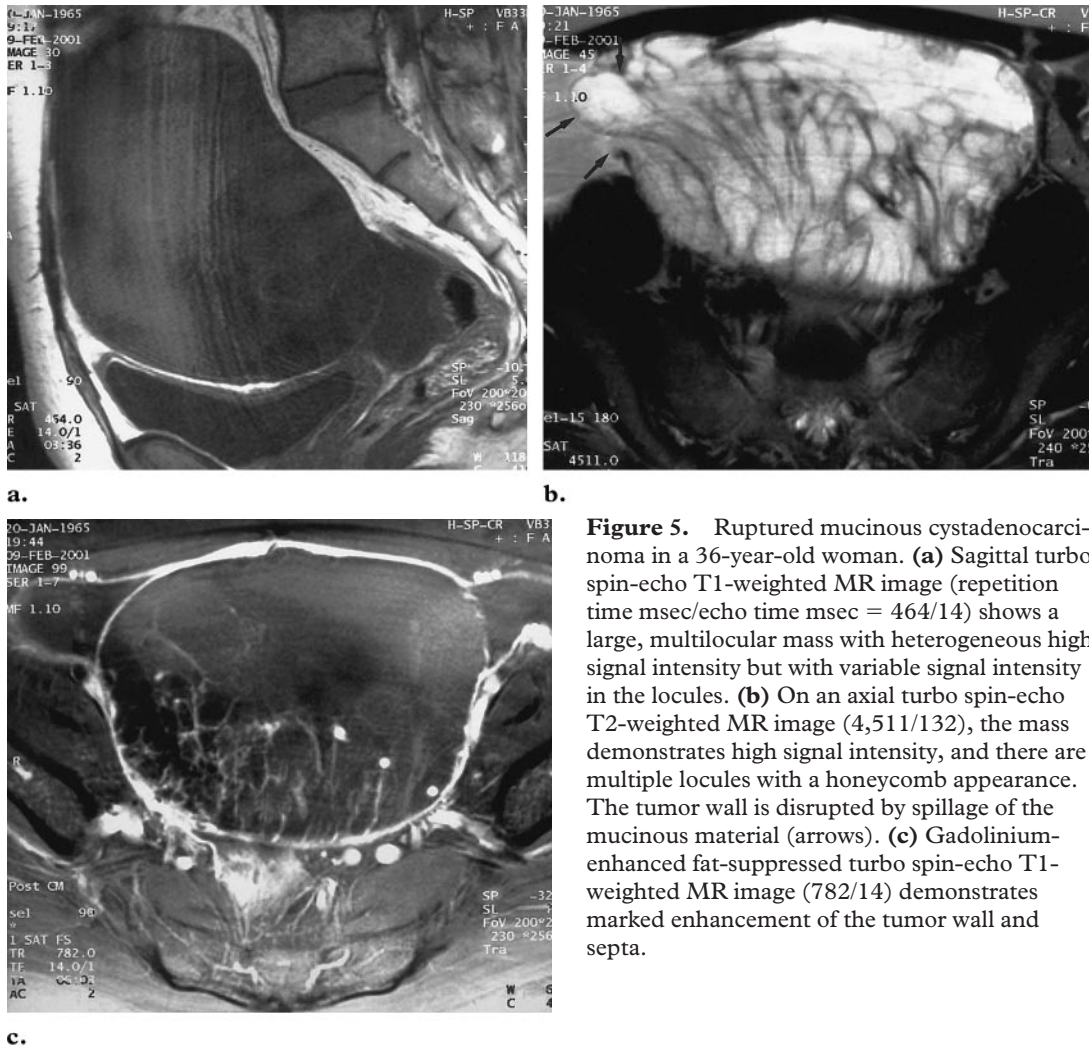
Ruptured mucinous cystadenocarcinoma in a 36-year-old woman. (a) Sagittal turbo spin-echo T1-weighted MR image (repetition time msec/echo time msec = 464/14) shows a large, multilocular mass with heterogeneous high signal intensity but with variable signal intensity in the locules. (b) On an axial turbo spin-echo T2-weighted MR image (4,511/132), the mass demonstrates high signal intensity, and there are multiple locules with a honeycomb appearance. The tumor wall is disrupted by spillage of the mucinous material (arrows). (c) Gadolinium-enhanced fat-suppressed turbo spin-echo T1-weighted MR image (782/14) demonstrates marked enhancement of the tumor wall and septa.
